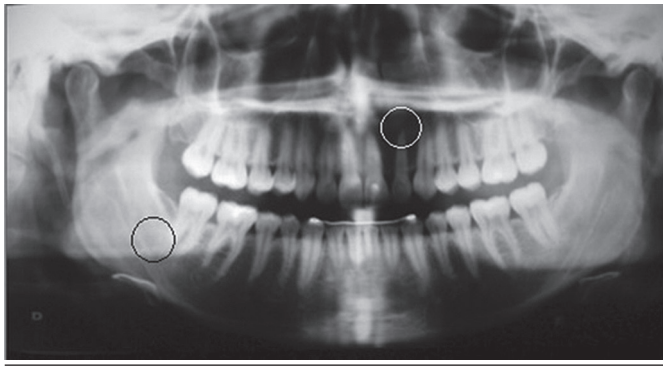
Panoramic radiograph prior to treatment: ROI test (white circle) and initial control (black circle) in the area before intralesional corticosteroid application
